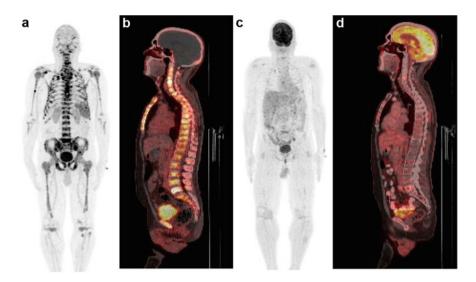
⁶⁸Ga-Pentixafor PET/CT in a 60-year-old male with multiple myeloma showing diffuse and focal tracer uptake in axial and appendicular skeleton (MIP image—a and sagittal fused PET/CT image—b), showing diffuse and focally increased tracer uptake in marrow and lytic bony lesions. The corresponding ¹⁸F-FDG PET images (c, d) did not show any abnormal uptake in marrow and elsewhere in the skeleton
